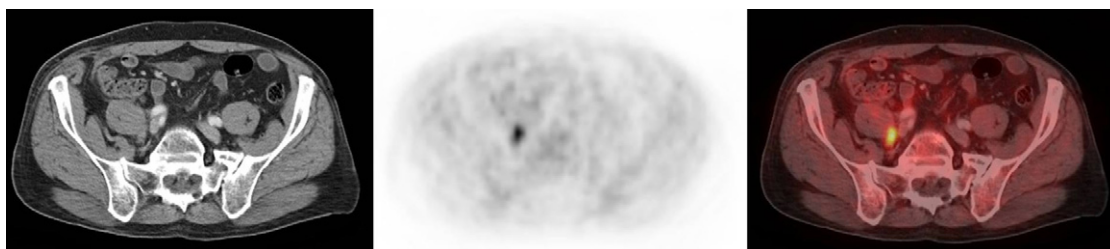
67-year-old patient with biochemical relapse after radical prostatectomy. ^{11}C -choline-PET/CT localised metastatic disease to a solitary lymph node metastasis that not fulfilled morphologic size criteria. Left: contrast-enhanced CT, middle: ^{11}C -choline-PET, right: ^{11}C -choline-PET/CT fusion.
